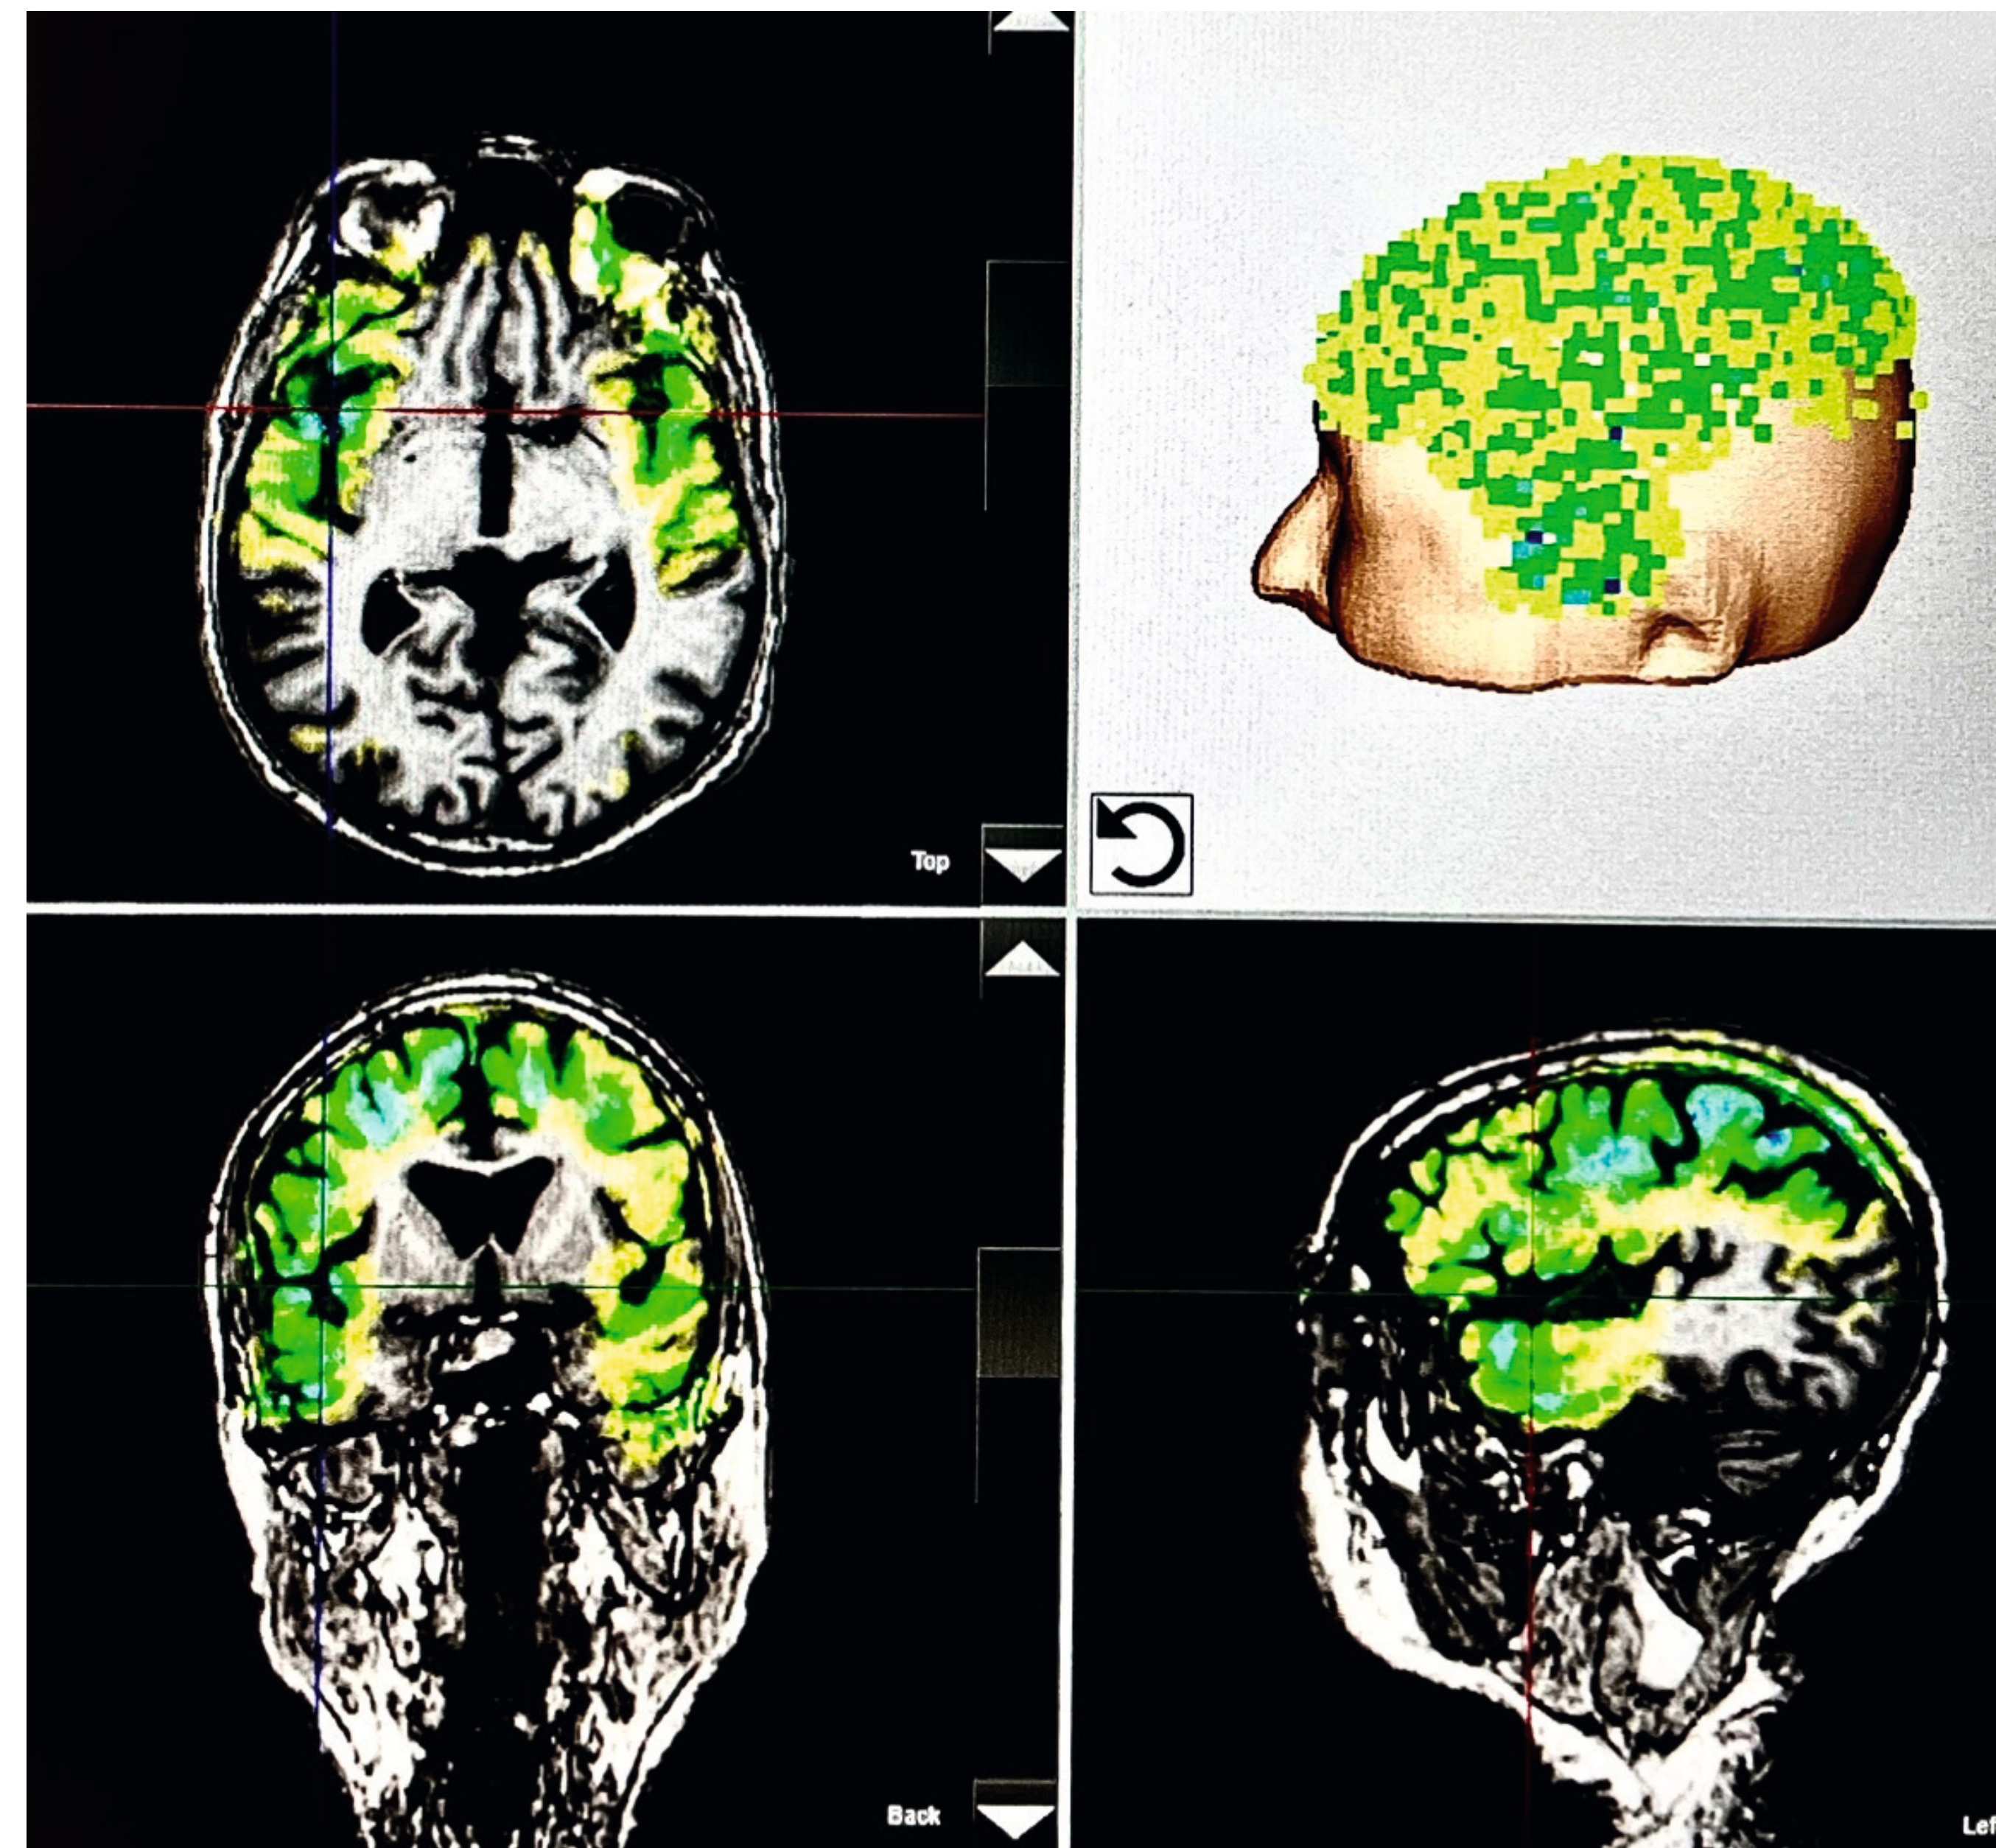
The application of the pulses was individually navigated by recent MR images of the patient (Fig. 2).
